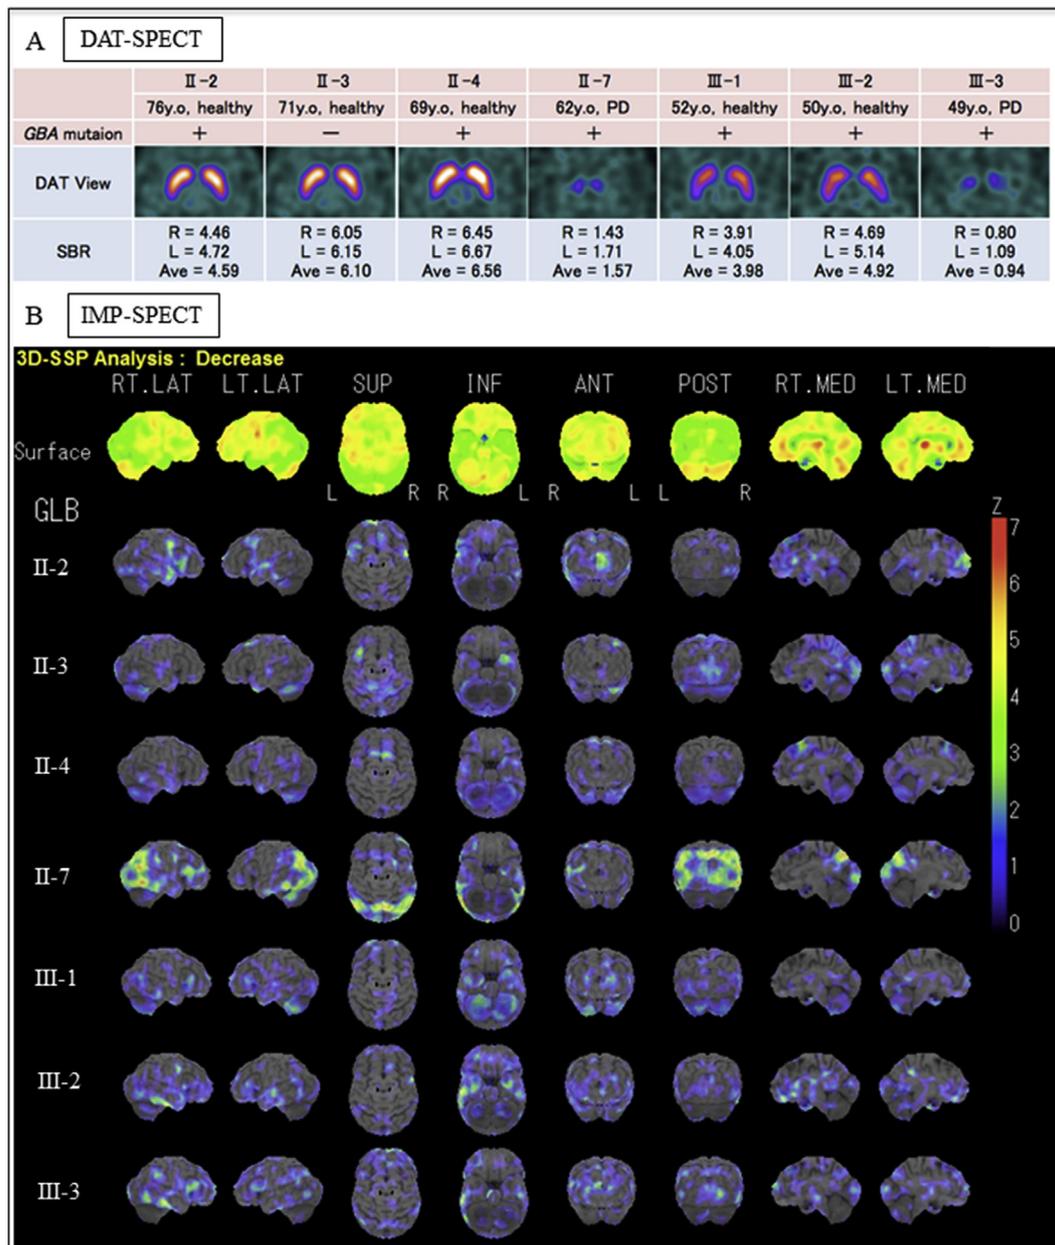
A - The visual results with DaTView software. [¹²³I] FP-CIT uptake was markedly reduced in the two patients (II-7 and III-3), and was slightly reduced in two clinically unaffected carriers (III-1 and III-2) in comparison with their ages. Signal loss was predominantly detected in the posterior dorsal putamen. [¹²³I] FP-CIT uptake was about the lower reference value limit in one clinically unaffected carrier (II-2). On the other hand, [¹²³I] FP-CIT uptake was normal in one unaffected carrier (II-4). B - The results of IMP-SPECT revealed the decreased blood flow in the occipital lobes on 3D-SSP analysis in one PD patient (II-7).
